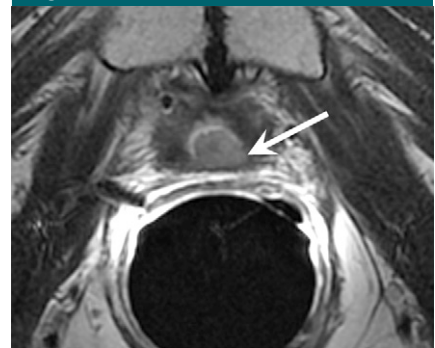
Transverse T2-weighted MR image in 59-year-old man who has undergone prostatectomy shows nodular soft-tissue mass (arrow) of intermediate to high signal intensity (compared with muscle), consistent with recurrent disease at the vesicourethral anastomosis.
